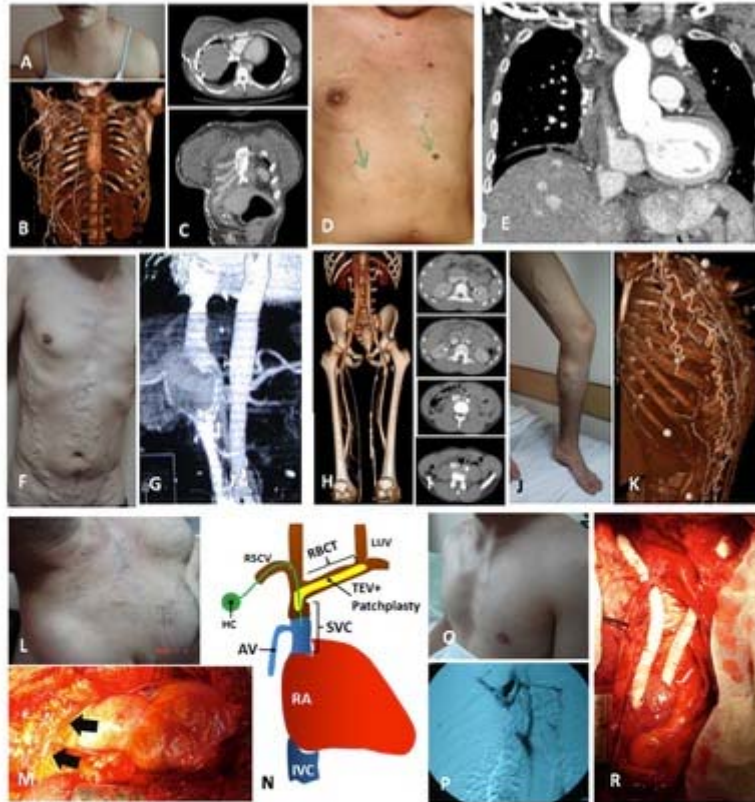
A CT venography of a 21-year-old female patient with SVCS due to Behçet's disease. Note the chest wall and epigastric venous collaterals due to extensive occlusion of the SVC, innominate and azygos (Type IV) (A-C). A CT venography of a 26-year-old man with SVCS and pulmonary artery aneurysm due to Behçet's disease. Note the clinical (arrows) and angiographic appearance (Type IV) of venous collaterals in the anterior chest wall of the patient (D, E, K). A 43-year-old patient with Behçet's disease presenting with diffuse venous collaterals in the anterior abdominal wall with aortic aneurysm, caval thrombosis and cardiac involvement (Type V according to Hamza's classification) (F, G). Clinical and angiographic appearance of a 15-year-old man with double IVC with no interiliac communication (Type 2A according to Morita classification) (H-J). Clinical presentation of venous collaterals in the neck and the upper region of chest due to SVC obstruction in a 55-year-old man (L). A longitudinal venotomy throughout proximal SVC and left brachiocephalic trunk was performed via sternotomy and left neck incision. Hickman catheter was removed through two different incisions on the chest wall; thrombo-endovenectomy, and finally patchplasty with pericardial patch (black arrows) (M, N). A picture showing venous collaterals due to SVC obstruction in a 26-year-old male patient with Behçet's disease (O); the same patient's contrast angiogram (P) and operative field showing bilateral jugulo-atrial bypass grafting by expanded externally supported polytetrafluoroethylene (ePTFE, 10 mm in diameter) (R). SVCS, superior vena cava syndrome; RSCV, right subclavian vein; AV, azygos vein; RA, right atrium; SVC, superior vena cava; IVC, inferior vena cava; LIJV, left internal jugular vein; TEV, thrombo-endovenectomy; HC, Hickman catheter; LBCT, left brachiocephalic trunk;
